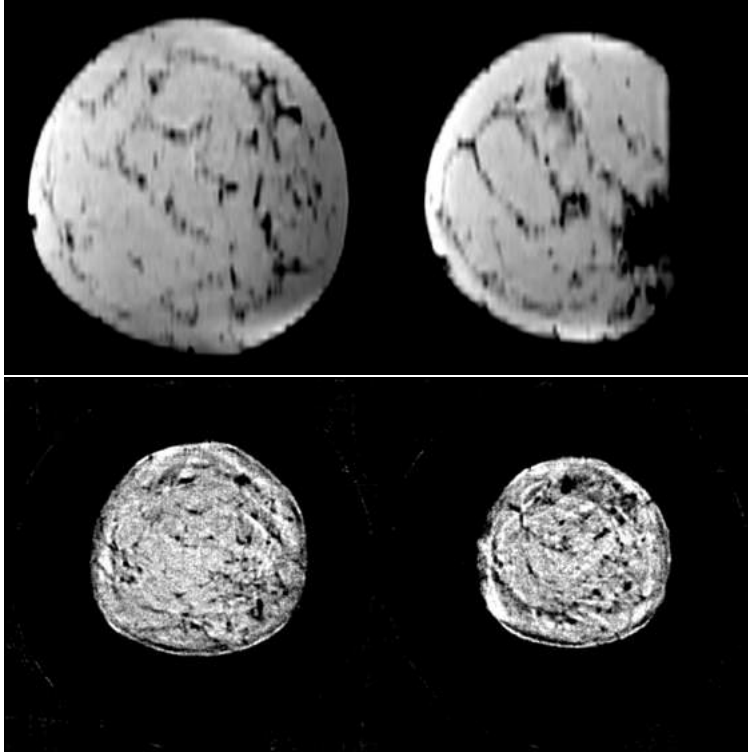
Series of MR and Waveform Tomography Sound Speed Images. Images consist of alternating rows of MR images and waveform sound speed images. Each vertical pair of MR and sound speed images correspond to approximately the same location in the patient.
